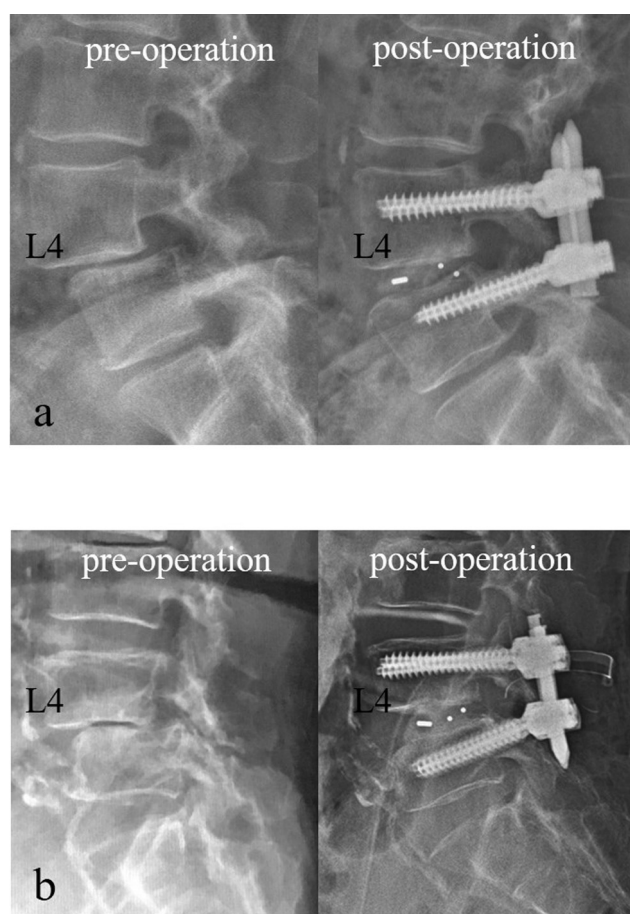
(a) Lateral radiographs before and after the surgery in case 1. Representative case of a 61-year-old woman who underwent full-endoscopic trans-Kambin triangle lumbar interbody fusion (full-endoscopic KLIF) for L4 degenerative spondylolisthesis. The Meyerding grade II olisthesis is reduced after surgery. (b) Lateral radiographs before and after the surgery in case 2. Representative case of an 83-year-old woman who underwent full-endoscopic KLIF for L4 degenerative spondylolisthesis. The Meyerding grade II olisthesis is reduced after surgery.
